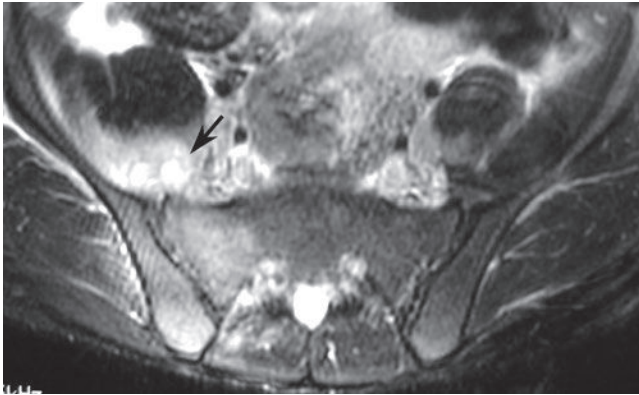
This axial T2-weighted image in a 15-year-old boy with infectious symptoms and complaints of low back pain shows increased T2-weighted signal in the region of the right sacroiliac joint and an associated soft-tissue component at the anterior aspect of the joint (arrow), compatible with a sacroiliac joint infection.
